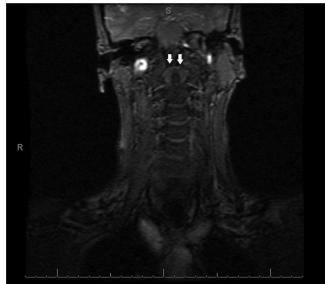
Coronal view of MRI of cervical spine showing symmetry of the odontoid lateral mass interspaces (arrows) with realignment of prior rotatory subluxation.
